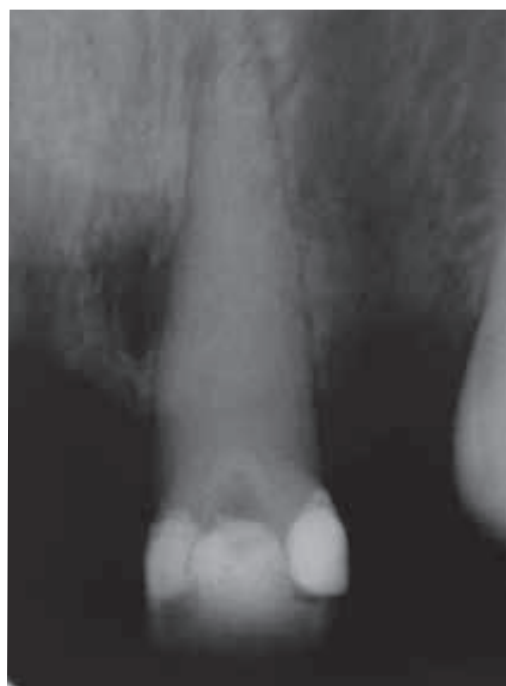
Initial X-ray showing a radiolucent area indicating internal root resorption at the middle third of the root canal
